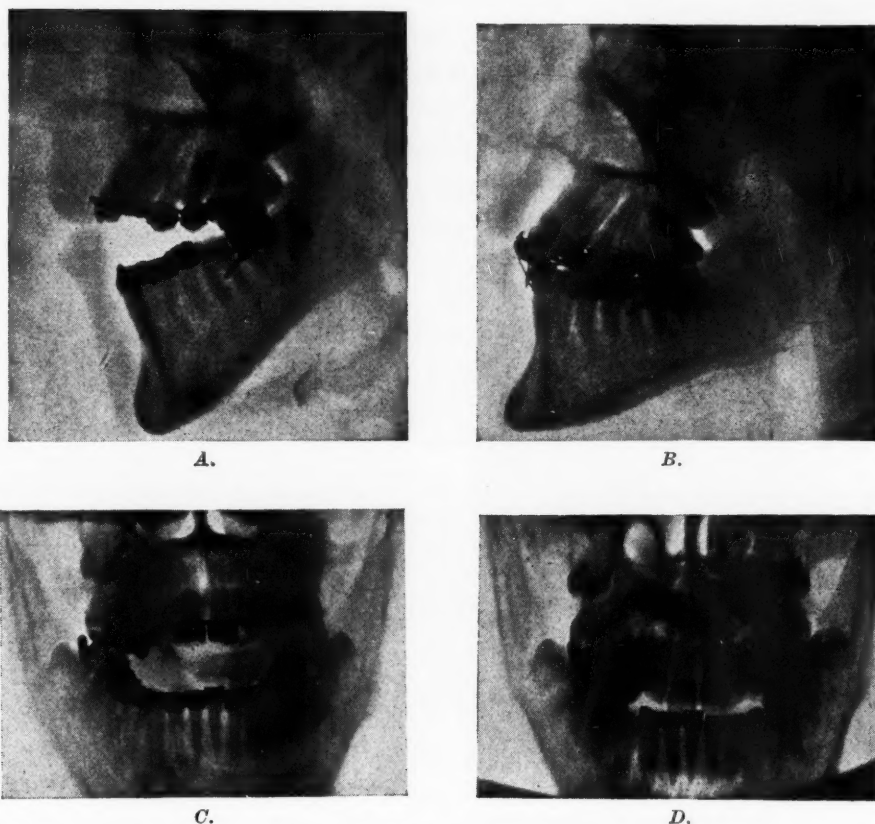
A and C, x-ray pictures of open-bite; B and D, the same case after treatment.
